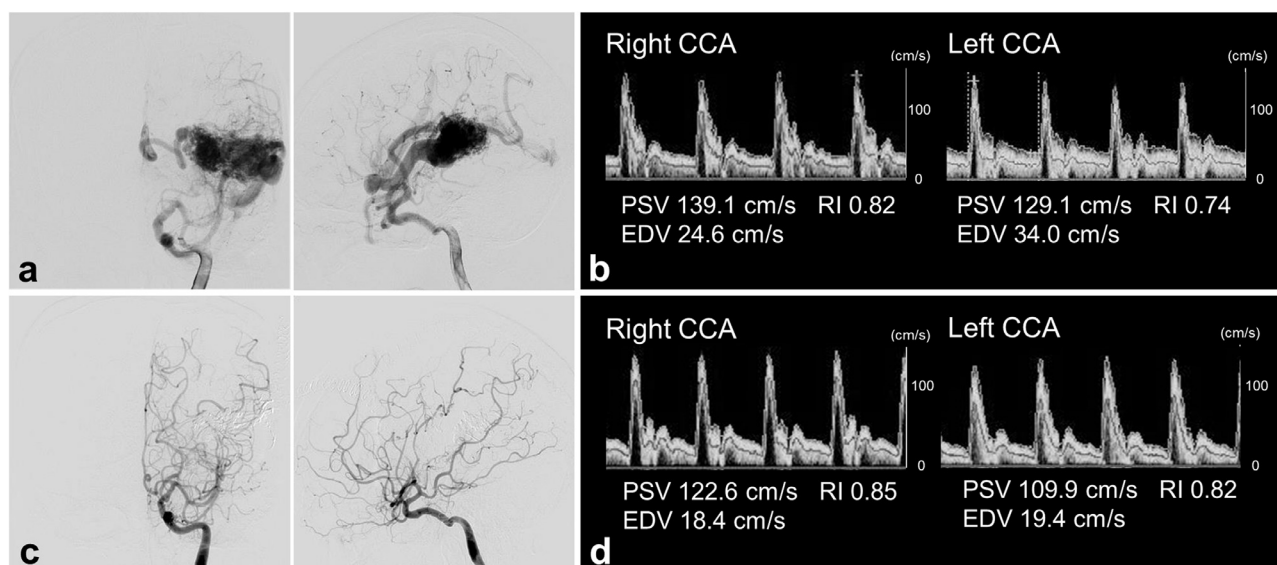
Case 1. (a) Preoperative left internal carotid arteriography (ICAG). Frontal (left) and lateral (right) projections show the arteriovenous malformation (AVM) and draining veins. (b) Preoperative carotid ultrasonography shows an increased end-diastolic flow velocity (EDV) in the left common carotid artery (CCA). PSV, peak systolic flow velocity; RI, resistance index. (c) Postoperative left ICAG. Frontal (left) and lateral (right) projections show that the AVM almost completely disappeared. (d) The elevated EDV in the left CCA is no longer evident in postoperative carotid ultrasonography.
